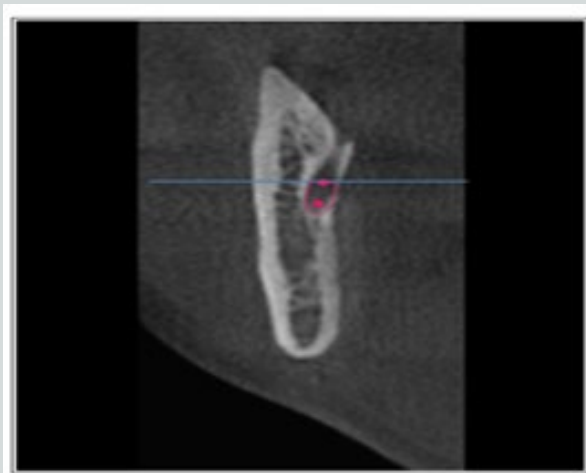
Showing Mandibular Coronal Section. Showing Cross sectional CBCT Image of Mandible for Localization of Mandibular Foramen
